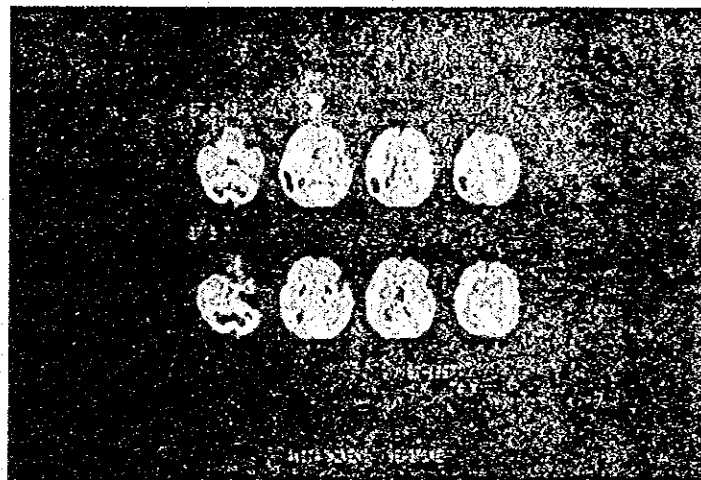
SPECT images using ^{123}IMP
